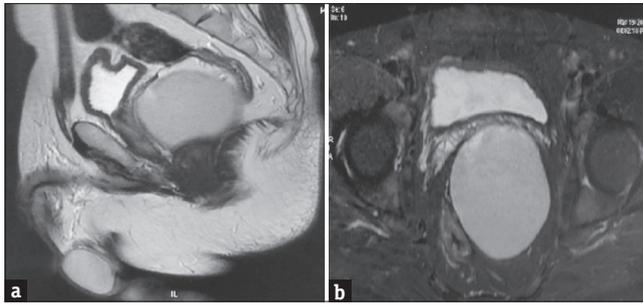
(a and b) MRI showing sagittal and transverse section respectively of a 82 × 71 × 70 mm lesion in the mesorectum causing right displacement of rectum and anterior displacement of urinary bladder
